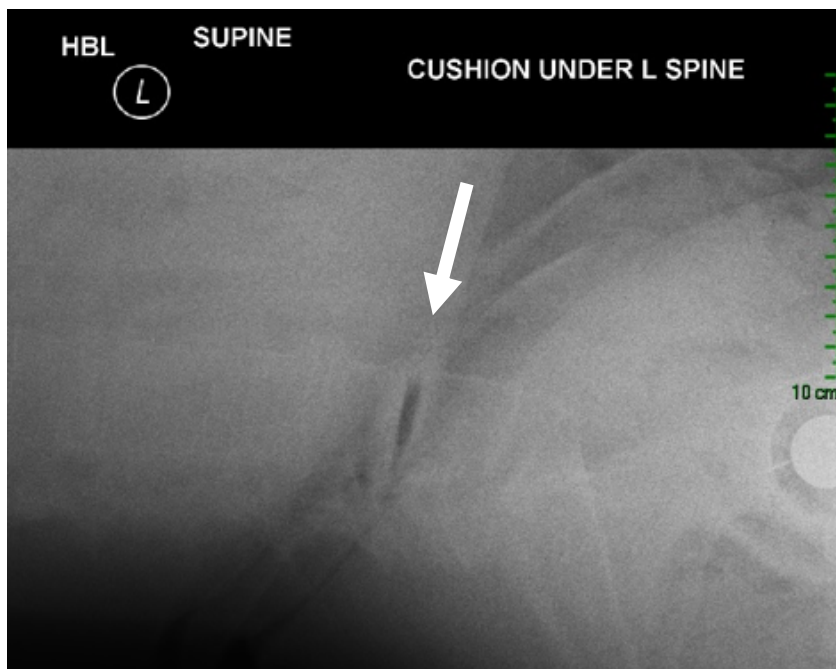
Radiograph displaying IDVP. The lumbar spine is extended over a cushion which opens the (black) vacuum at L45 (white arrow). The patient subsequently received an oblique anterior fusion, which both stabilised L45 and restored lordosis. Plain radiographs were not used in the research given the unpredictable rate of diagnosis.
